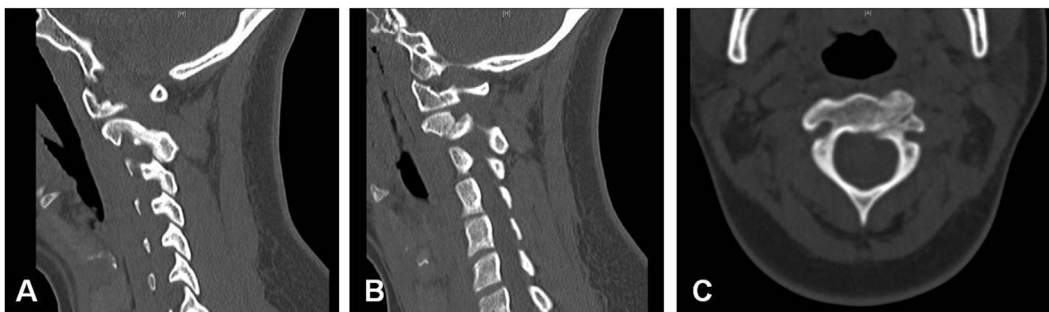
CT demonstrating healing of the bilateral pars interarticularis of C2 fractures, also known as Hangman's fractures in the sagittal plane (A and B), and axial plane (C) following 3 months of crown halo vest placement.
